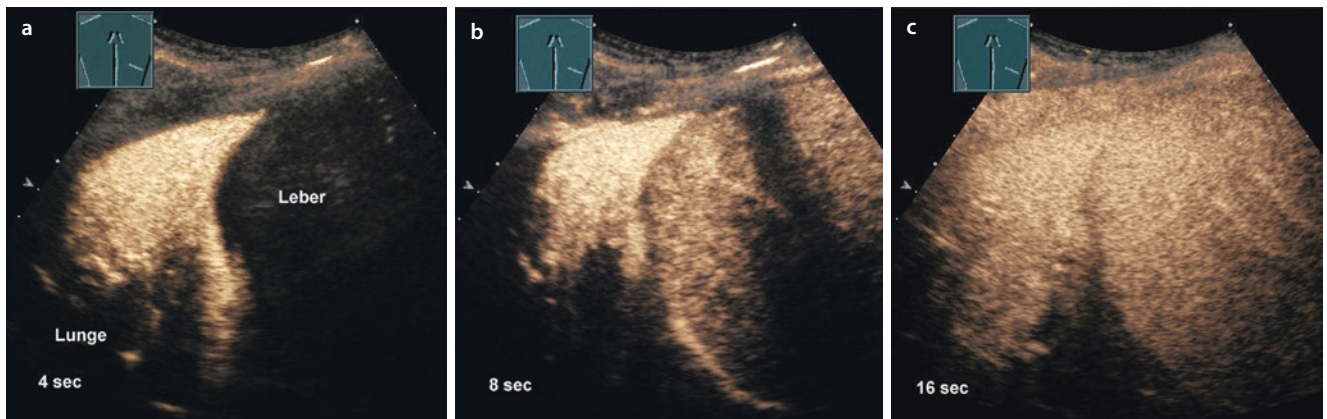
Signal-enhanced sonography in pneumonia. The saturation starts very early and achieves its maximum after 5–10 s
